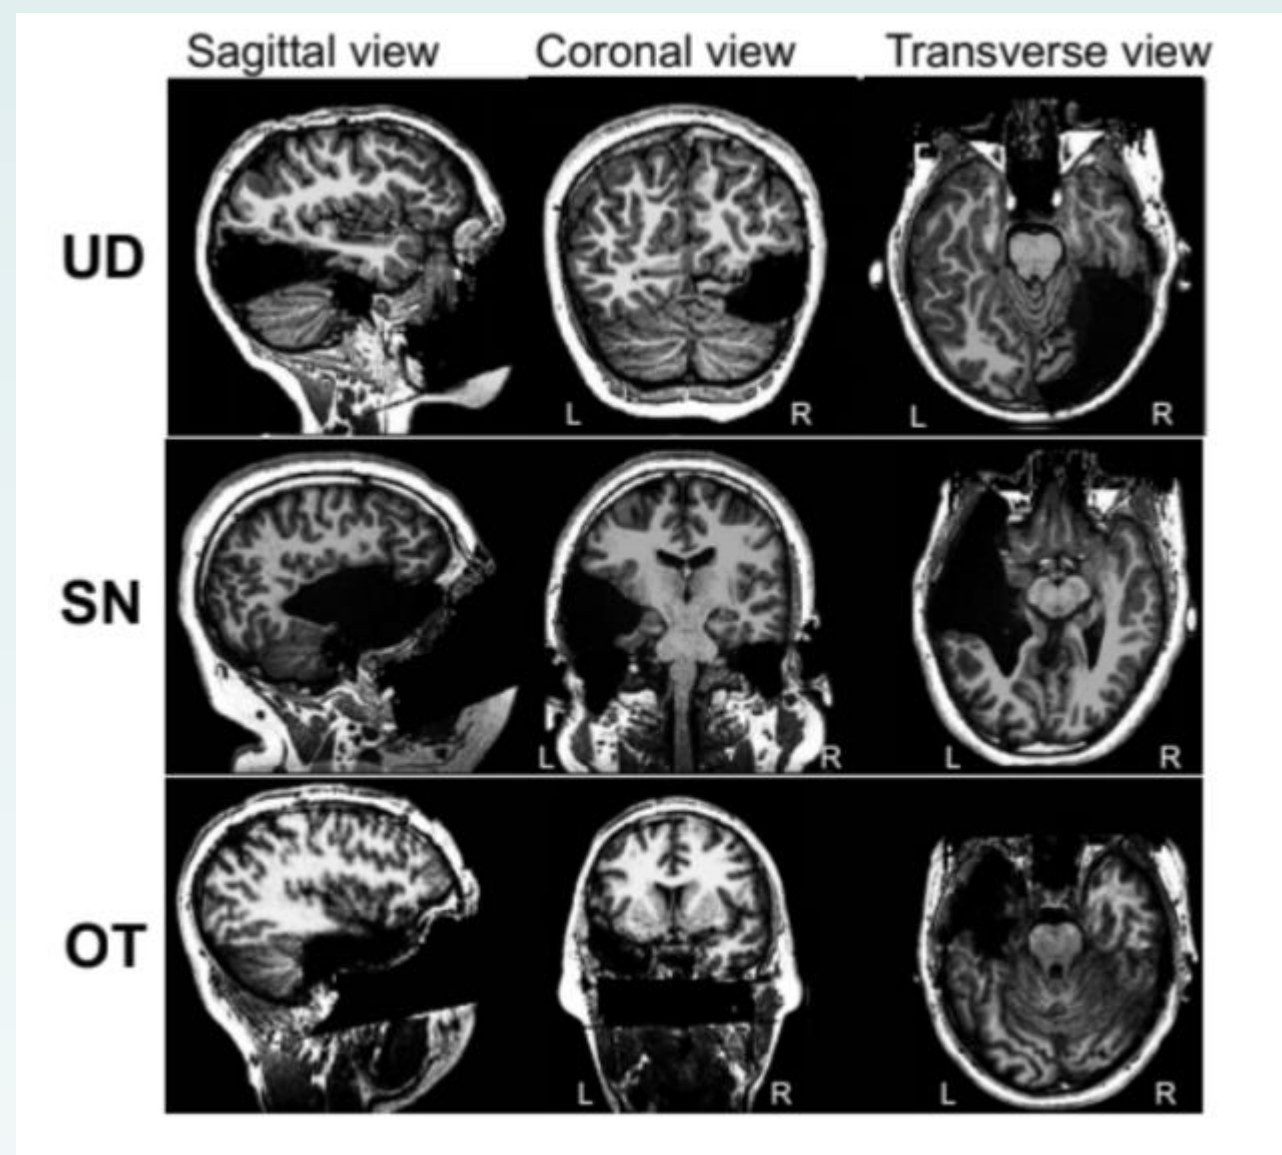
Figure One: Structural MRI scans of three patients with lobectomies. This represents an example of brain silences [1]
